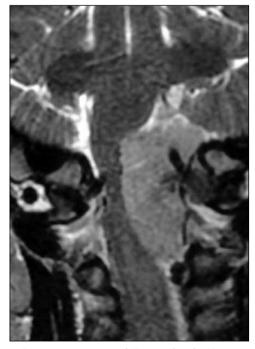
Preoperative coronal T2-weighted MR image shows slightly hyper intense tumor with important cerebrospinal tract compression.
